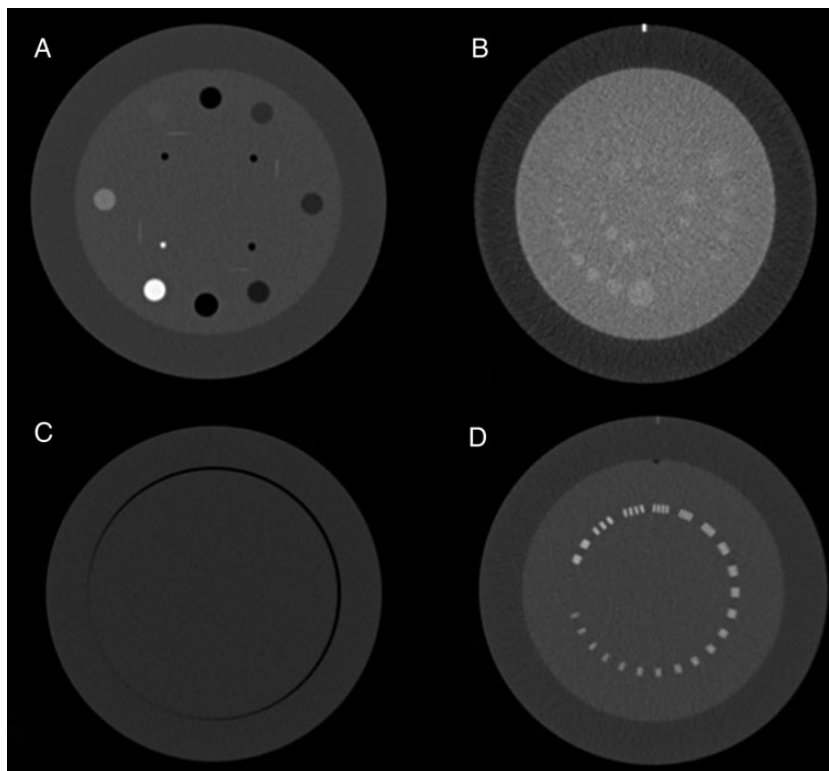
CT images of Catphan[®] 600 modules. (A) CTP 404, (B) CTP 515, (C) CTP 486, (D) CTP 591.
